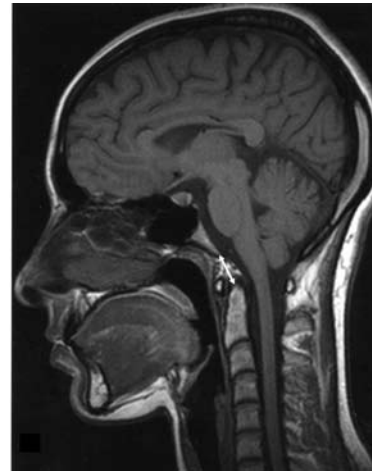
Basion-dens interval on T1 weighted magnetic resonance image.
